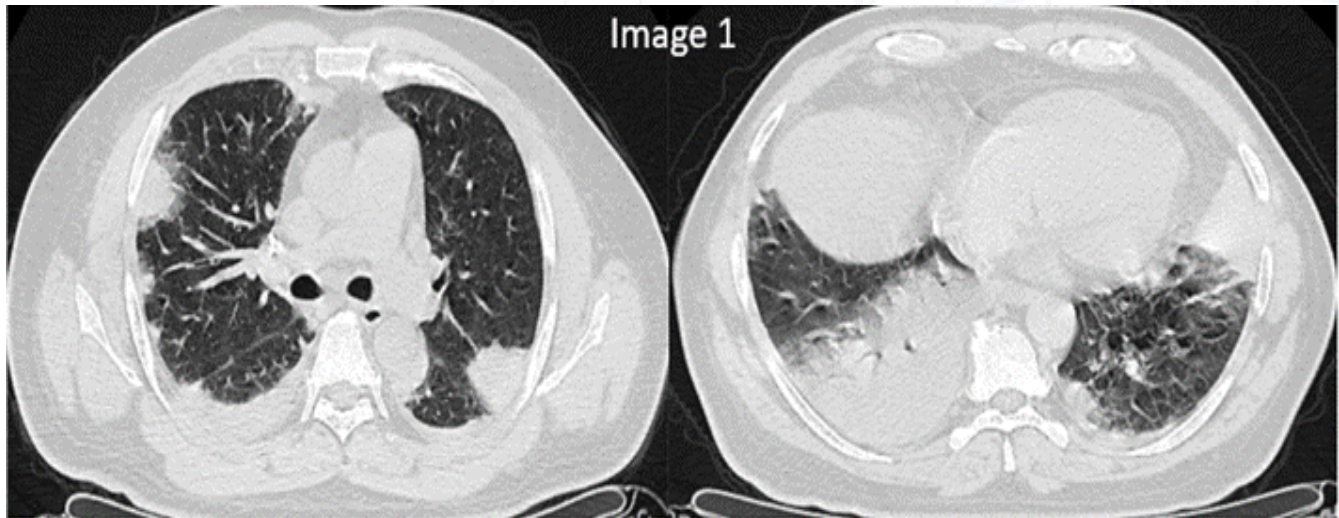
Chest CT in lung window. Axial cuts at different levels. November 2021. Multilobar consolidation in upper and lower right lobe, left lower lobe and lingula. Bilateral pleural effusion with right predominance
